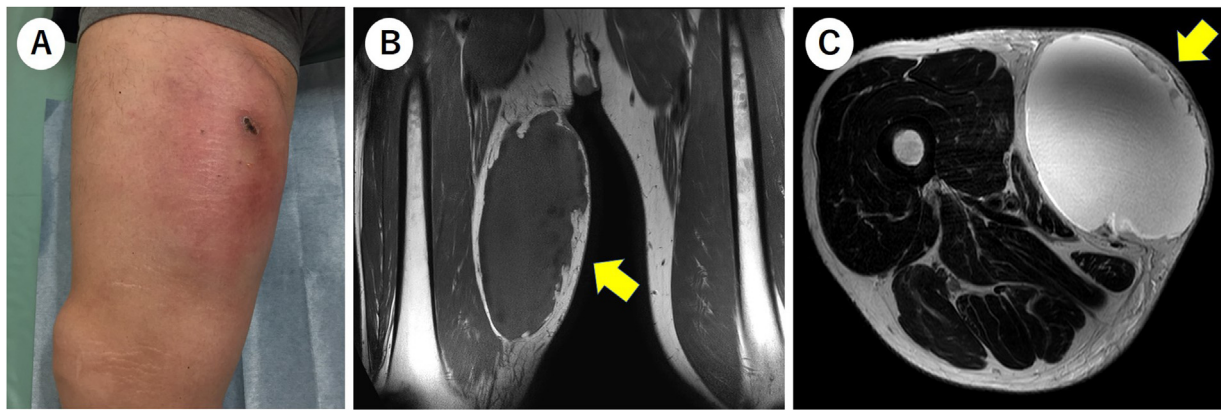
Photograph and MR images before surgery.
